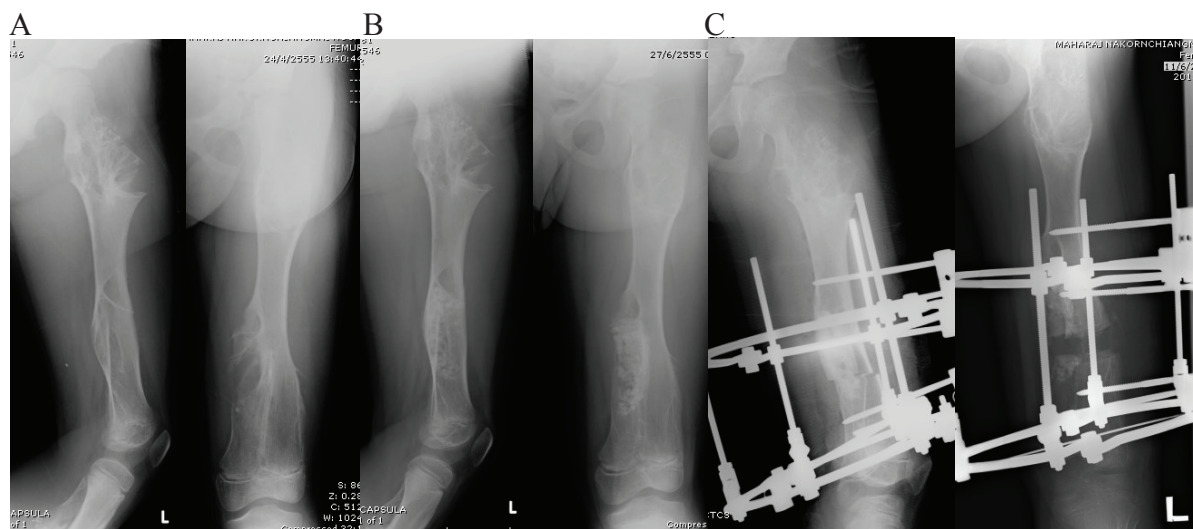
An 8-year old boy presented with left thigh swelling with hip and thigh pain on movement. A, Pre-operative radiographs showed multiple, radiolucent, well-defined, elongated shape lesions run parallel to bone axis at metaphysis extended to diaphysis of left distal femur. B, After the operation (curettage with hydroxyapatite bone graft), the lesions were filled with HA with little new bone formation around. C, Post-operative corrective osteotomy with Ilizarov bone lengthening. (The patient is continuously retaining the Ilizarov)
